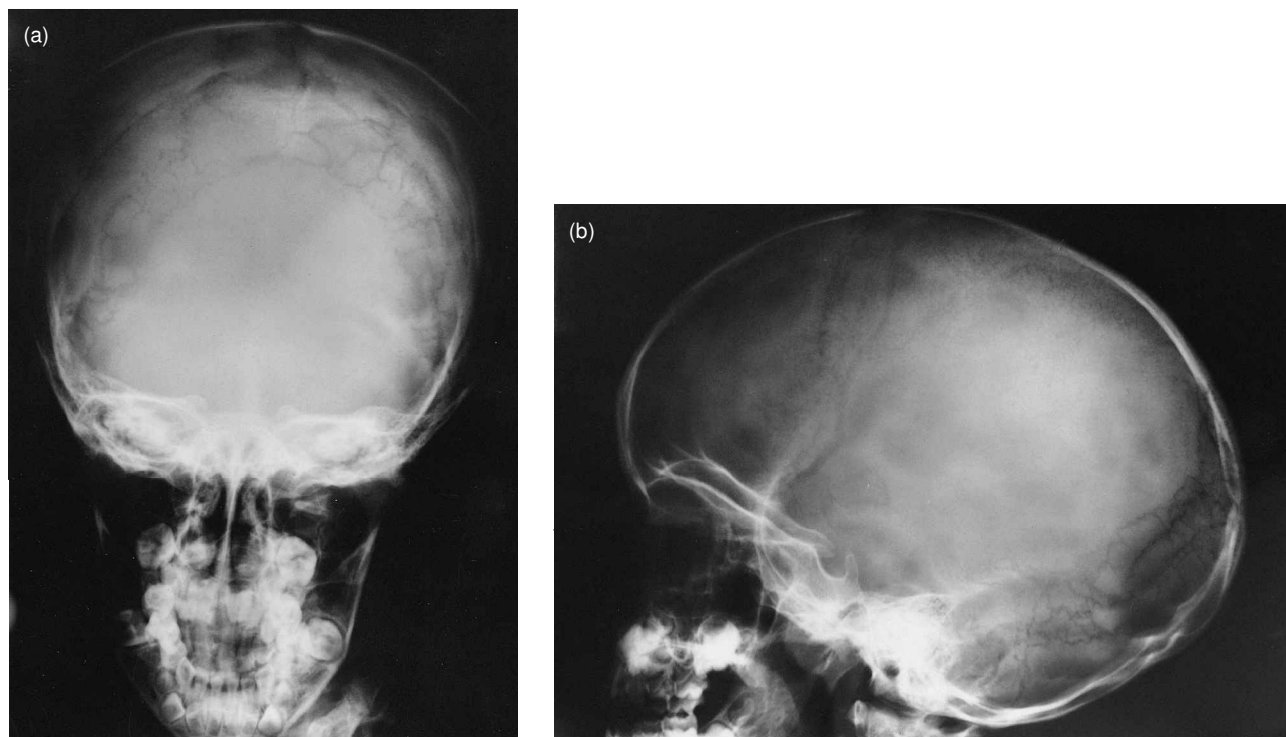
X-rays of the skull in our second patient taken at the age of 4 years in (a) antero-posterior and (b) lateral projections. Both demonstrate wormian bones involving the lambdoidal sutures, and a patent anterior fontanel.
